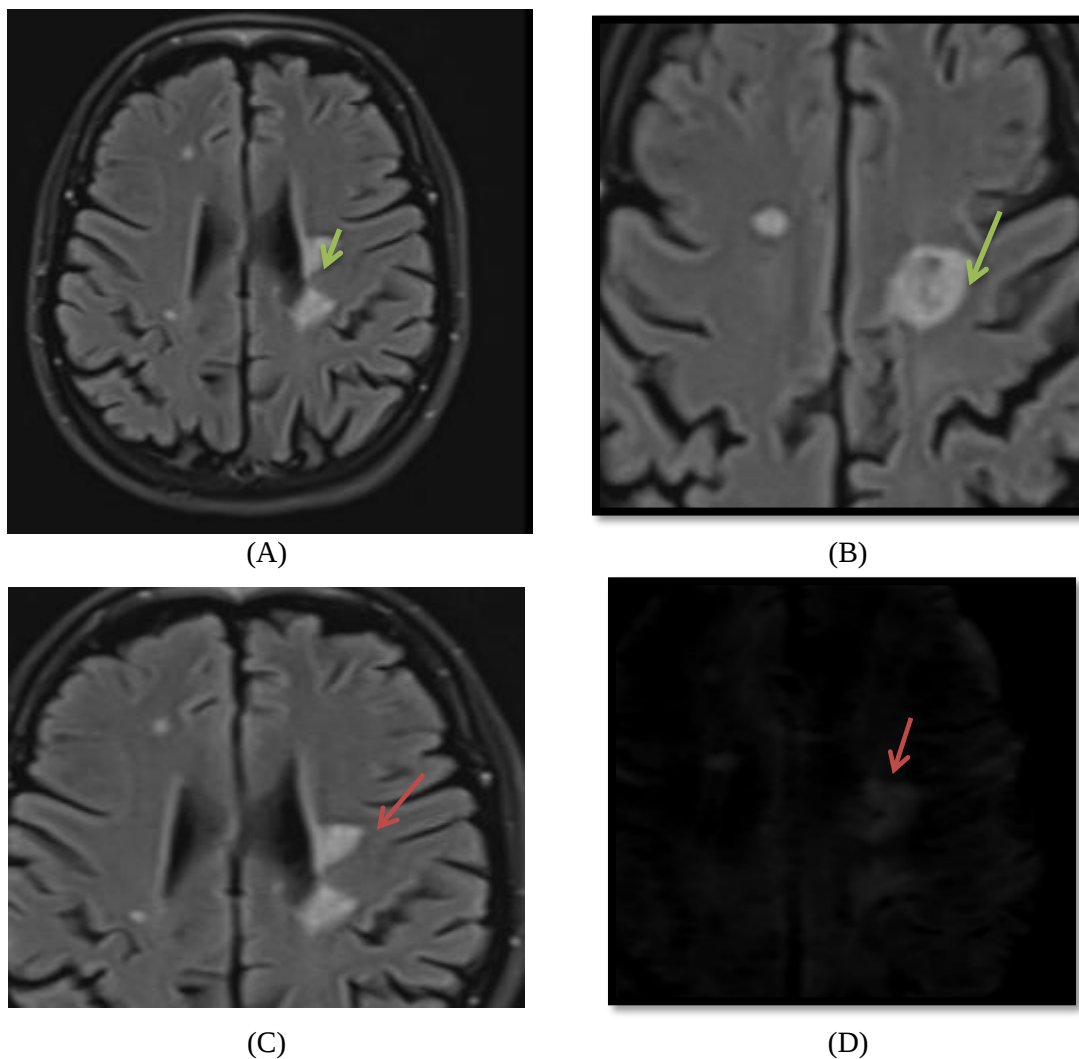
A) A periventricular lesion (green arrow) demonstrated the central vein signs on 3D FLAIR. B) Central vein sign closer view on axial 3D FLAIR. C) Another FLAIR bright lesion was seen on 3D FLAIR, which fails to show the central vein sign. D) SWI showing central vein sign in one of the lesions more evident compared to 3D FLAIR.
